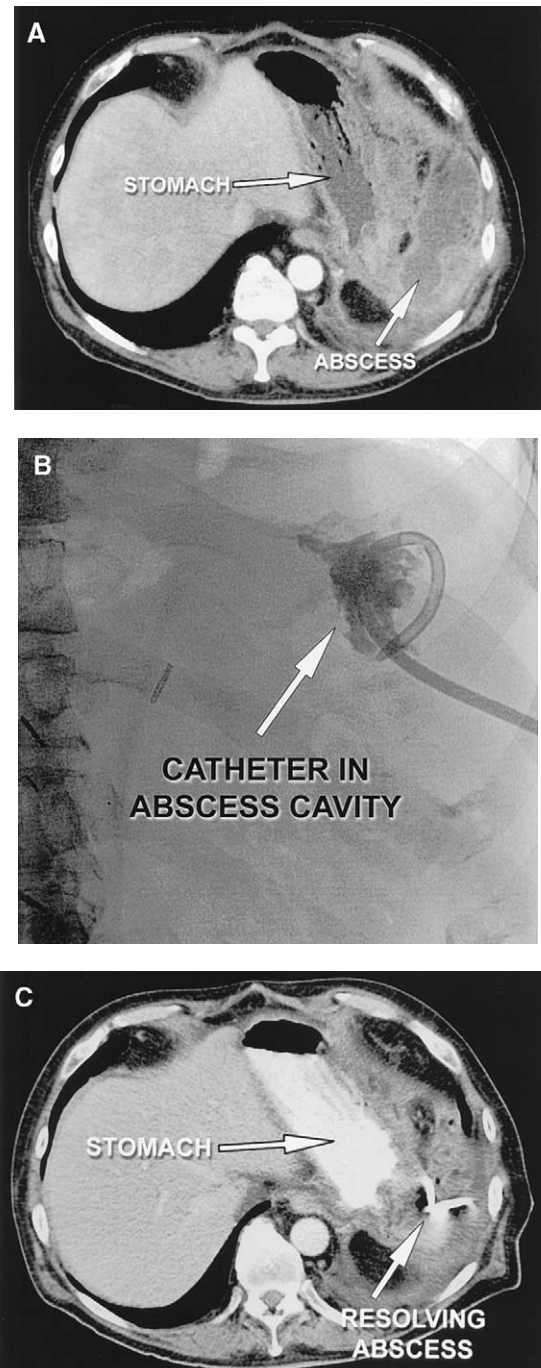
Intra-abdominal abscess drainage. These images are from a patient who underwent total pancreaticoduodenectomy with en bloc splenectomy and subsequently developed an abscess in the left upper quadrant. A, CT scan demonstrating a heterogeneous 12×4 cm abscess lateral to the stomach in the left upper quadrant. B, Image demonstrating percutaneously placed drain. Dye injection through the drain shows filling of the abscess cavity. C, Postdrainage CT scan shows drain in place in the left upper quadrant, with marked decrease in the size of the fluid collection.
